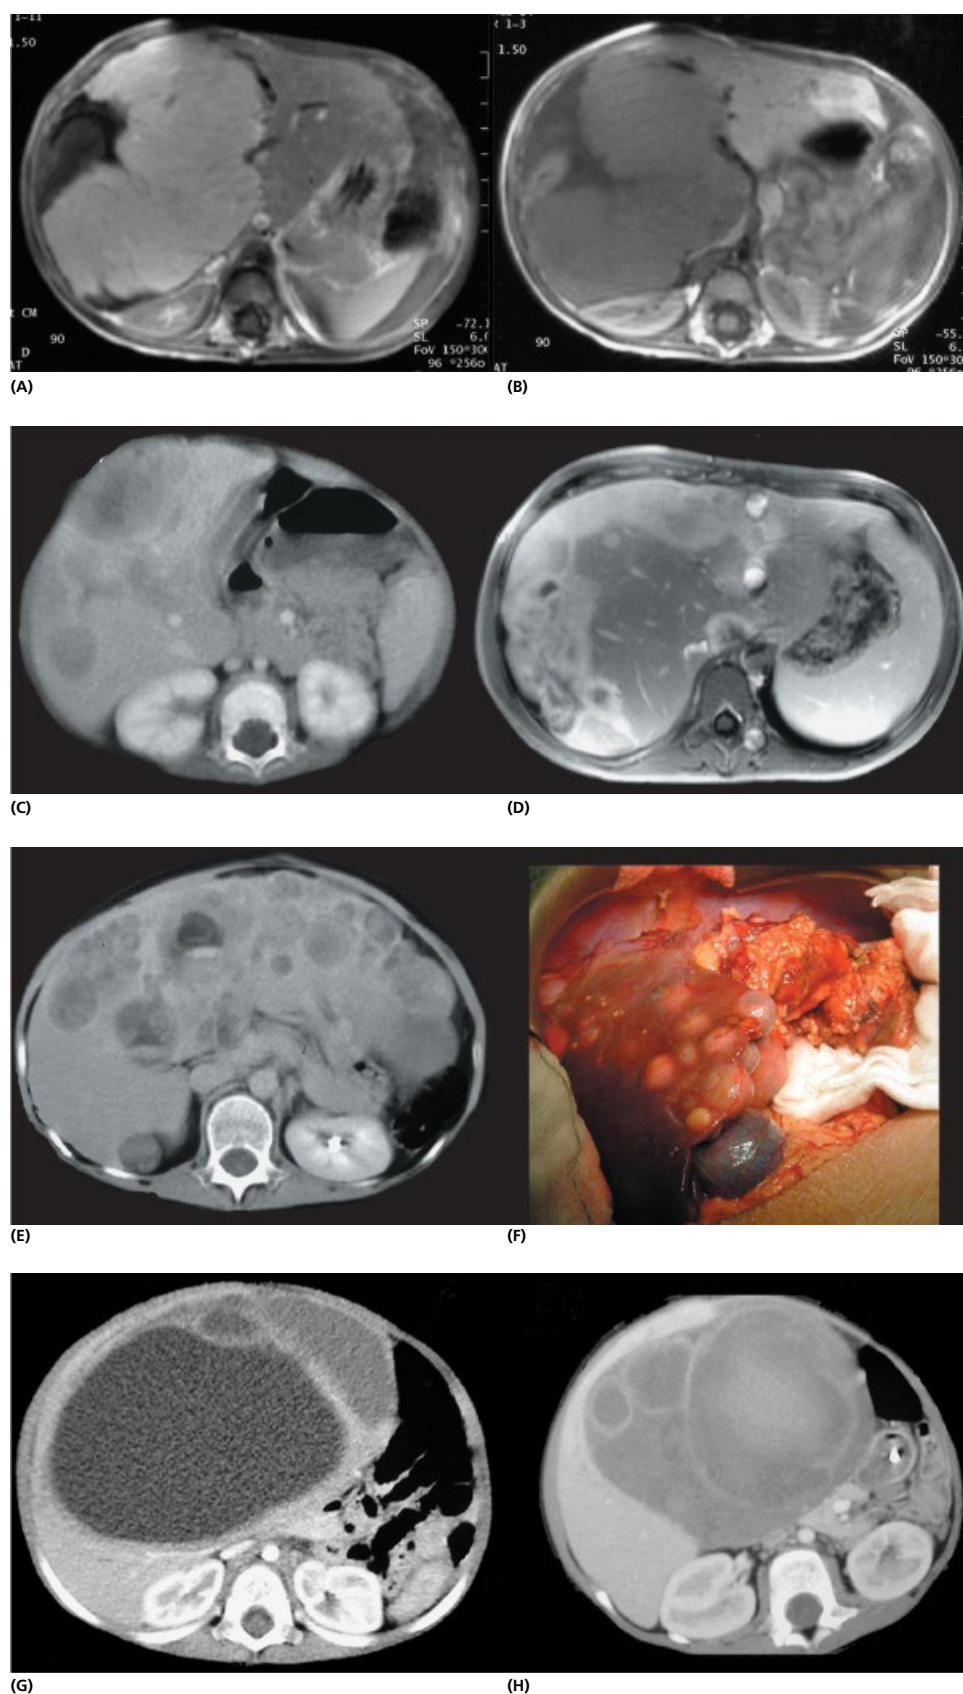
Hepatic tumors imaged by CT scanning, which demonstrates a large hepatoblastoma before (A) and after (B) intravenous contrast. It may also help to differentiate solid tumors such as hepatoblastoma (C), epitheloid hemangioendothelioma (D), and hepatocarcinoma (E) from cystic tumors such as mesenchymal hamartoma (G) and sarcoma (H). The cut surface of a hepatocarcinoma is shown in (F).
